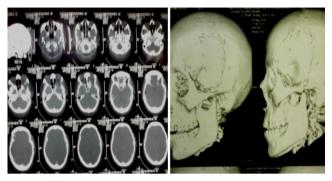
Postoperative CT brain showing excision of tumour and repair of the defect using methyl methacrylate
